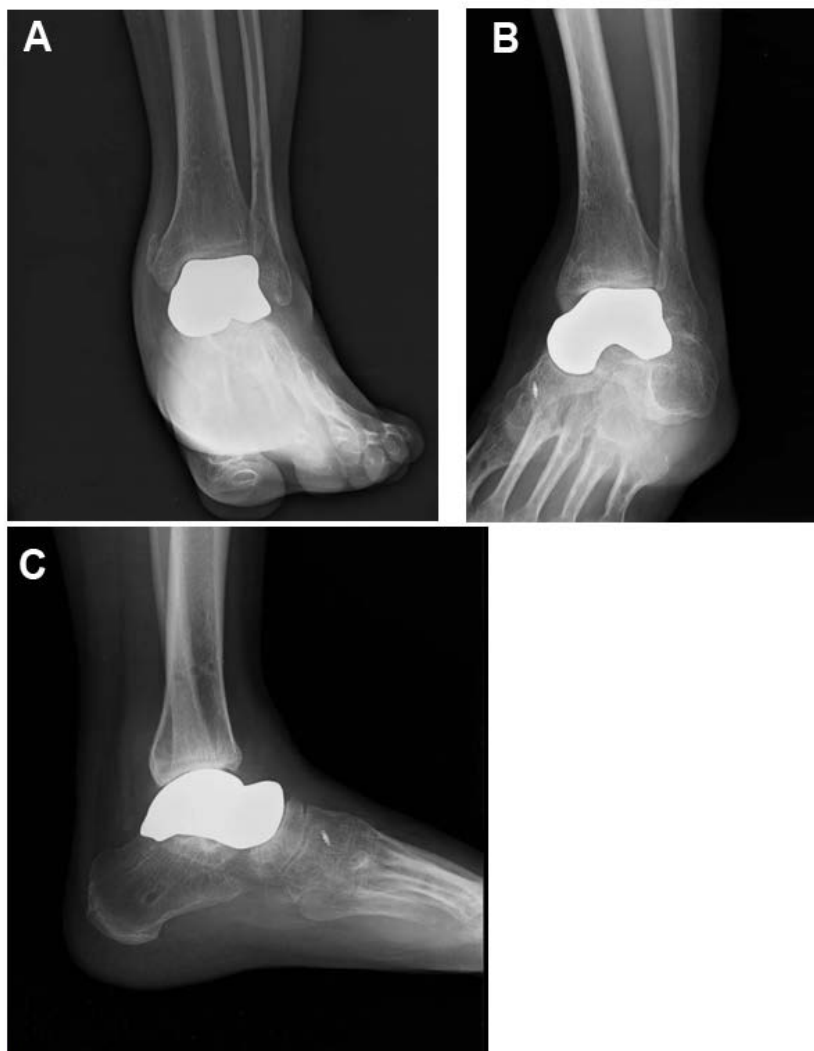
The postoperative radiographs showed the total talar prosthesis implant which was well seated in the ankle mortise, talocalcaneal, and talonavicular articulations, A) anteroposterior, B) mortise, and C) lateral radiographs.
